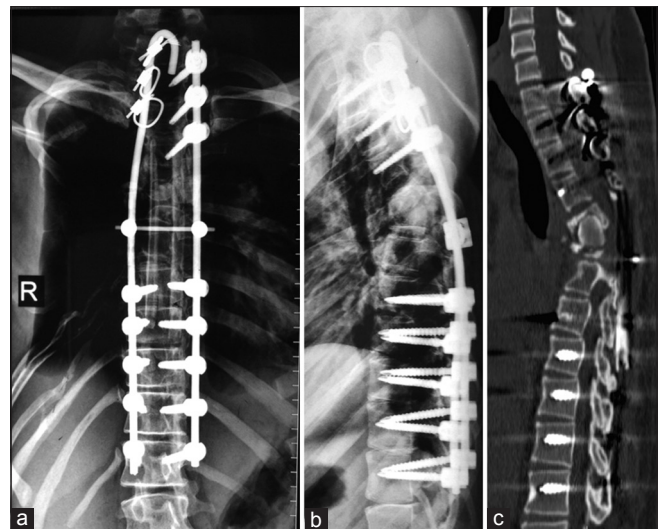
(a and b) Anteroposterior and lateral radiographs of dorsal spine at 7 months followup showing maintenance of alignment. (c) Computed tomography scan at 7 months following anterior reconstruction showing that tricortical graft has not resorbed but no fusion at graft host bone interface
